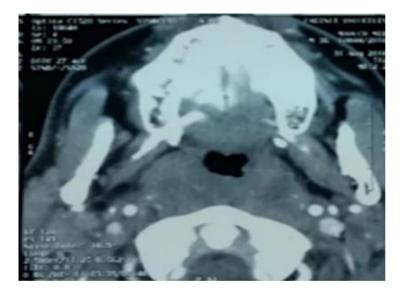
CT scan showing cavum infiltration
